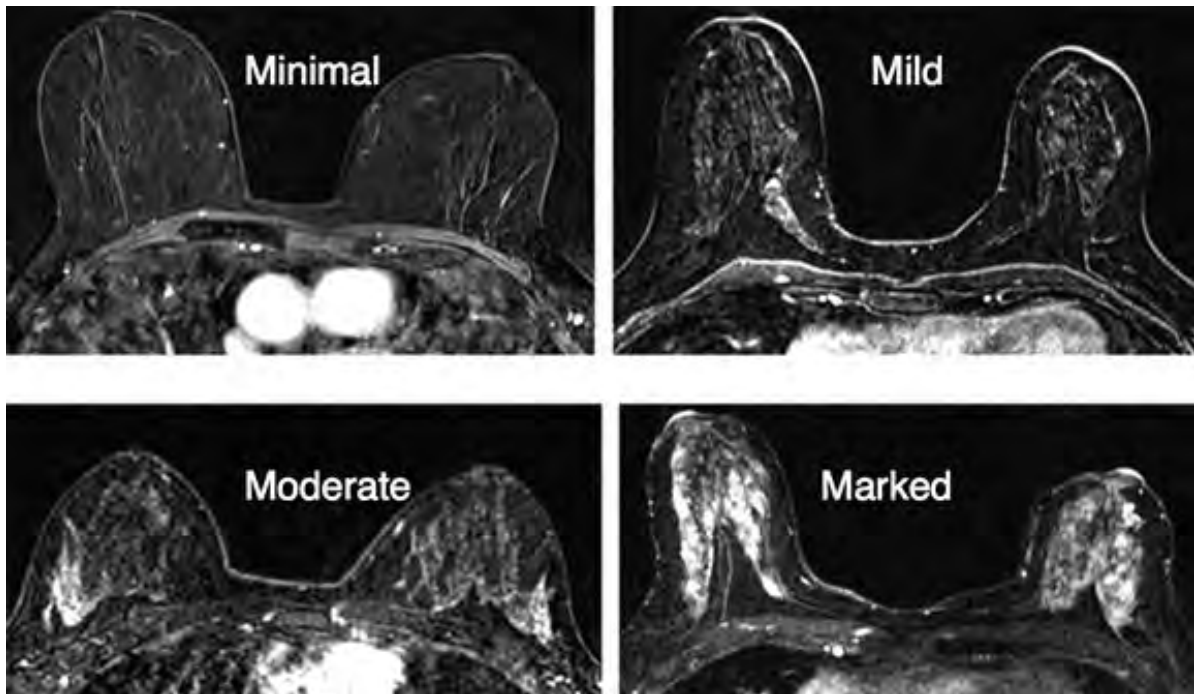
BI-RADS categories of background parenchymal enhancement (BPE) assessed on breast MRI (by increasing order): minimal, mild, moderate, and marked
